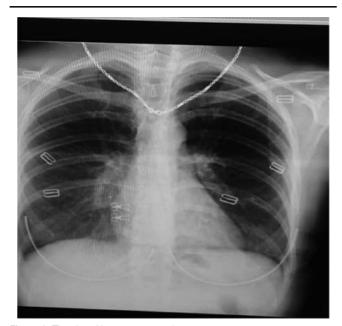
The chest X-ray were normal.
